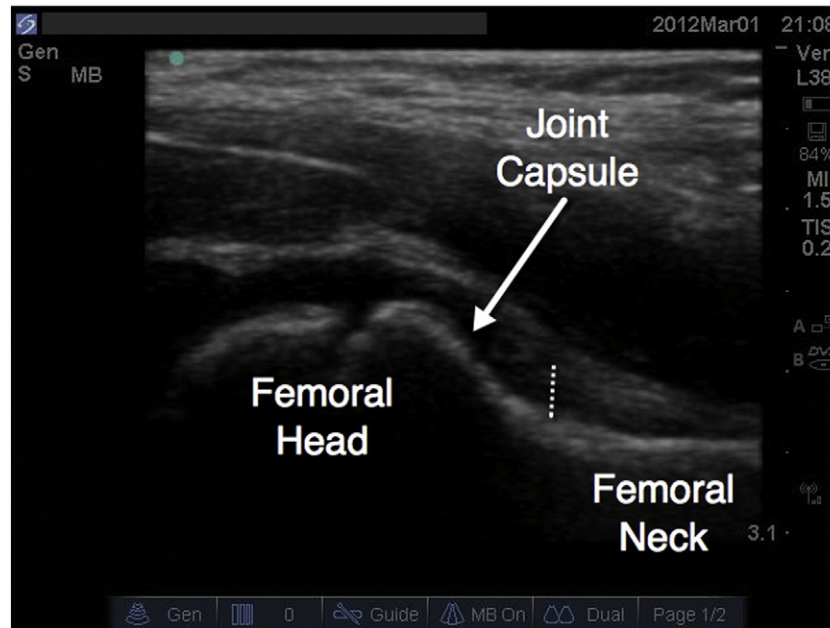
Normal hip ultrasound showing the femoral head, femoral neck, and the hypoechoic area representing the joint capsule. The dotted line is where the distance in the joint capsule is measured for a hypoechoic effusion. The measurement here is 3 mm and normal; abnormal will be discussed in subsequent sections.
